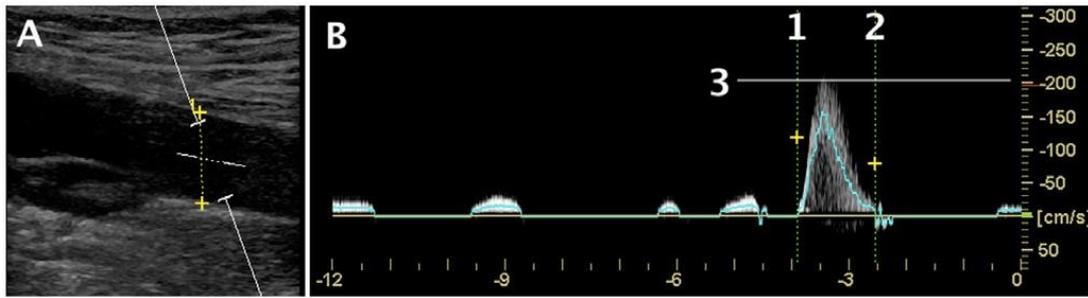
Representative Doppler ultrasound capture window used for blood flow analysis. A. Representative screen shot from Duplex Doppler ultrasound measuring popliteal vein diameter. B. Representative screen shot from Duplex Doppler ultrasound showing blood flow waveform in response to NMES stimulation. For haemodynamic analysis each waveform produced in response to the intervention is analysed by positioning callipers appropriately. Peak venous velocity (cm/s, line 3), time averaged mean velocity (TAMEAN (cm/s), mean flow between lines 1 and 2) and volume flow (mL/min, volume flow between lines 1 and 2). The X-axis reflects time in seconds.
